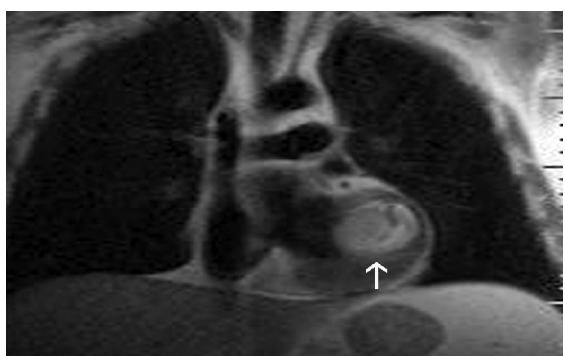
Static image from cardiac MRI examination performed with cine true fast imaging with steady-state precession shows hydatid cyst (arrow) with hypo-intense ring-shaped thick wall at the left ventricle lateral wall in coronal T2 weighted dark-blood MR image.
